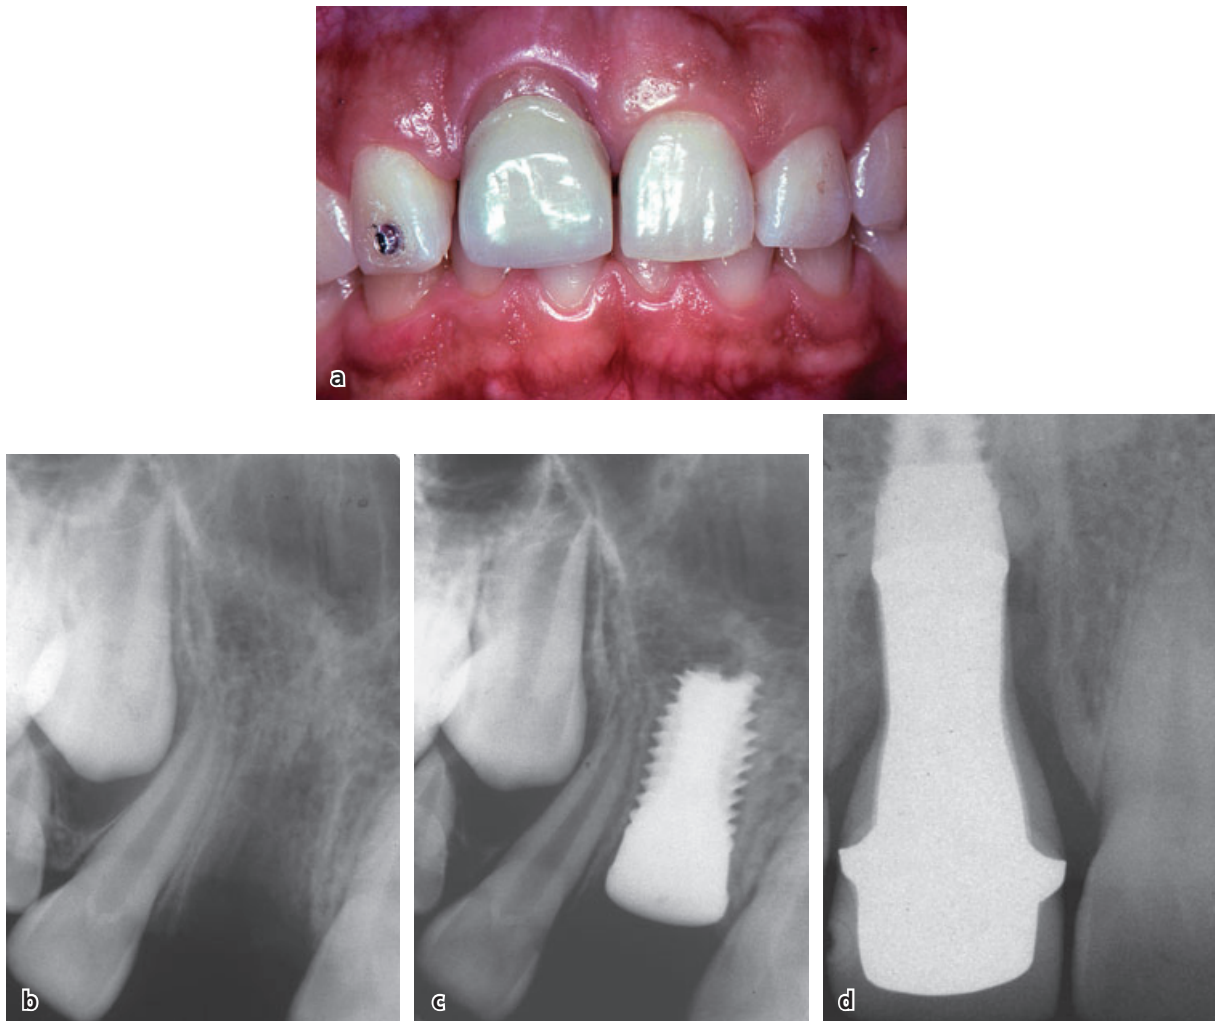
(a) Oral implant placed prematurely (at age 9 years) in a growing patient. The implant did not follow the growth development of the alveolar process resulting in the need for multiple (three times) replacement of the prosthetic reconstruction until adolescence. Unsatisfactory esthetic outcomes persist. Radiographic documentation: (b) Following traumatic loss of tooth 11 at age 9 years. (c) Implant placement in the growing maxilla. (d) Oral implant 9 years after placement and third single tooth crown reconstruction (Courtesy of G.E. Salvi, Berne, Switzerland.)
